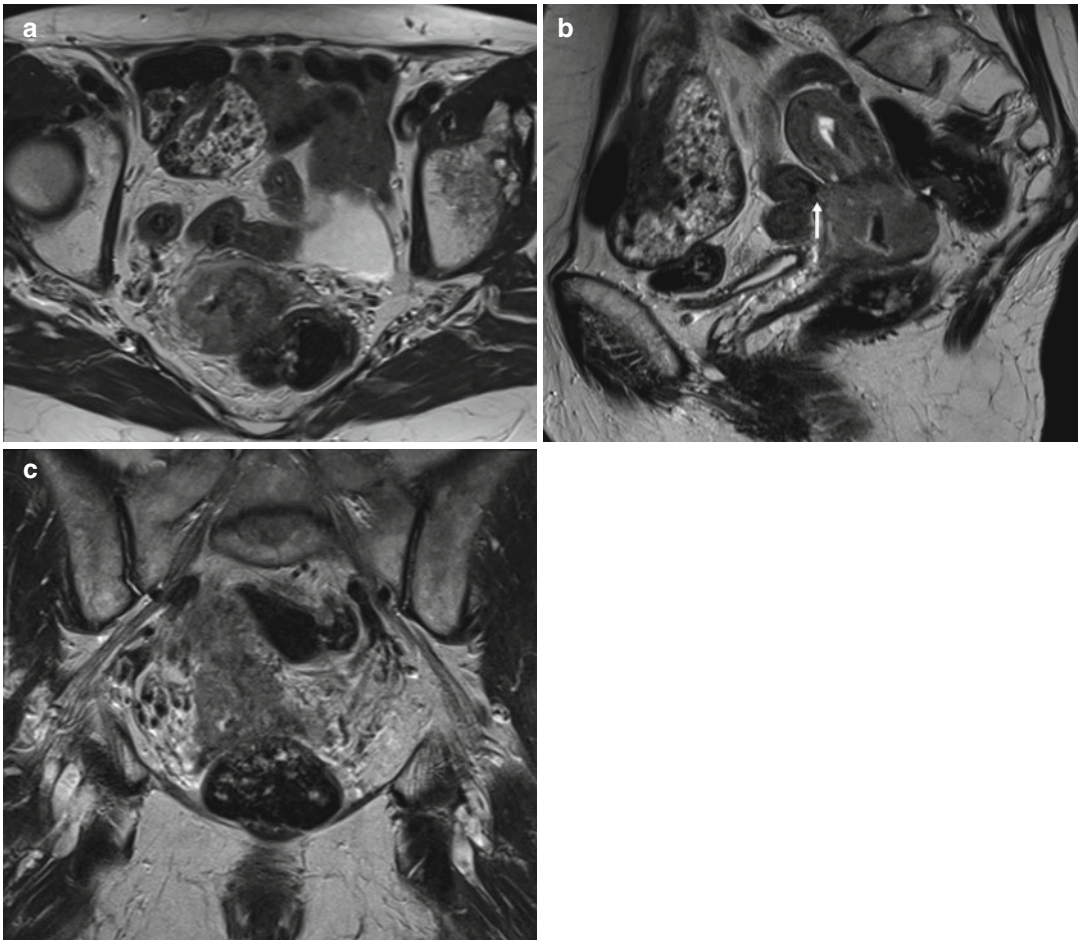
Squamous cell carcinoma of the cervix in a 79-year-old female. T2-weighted transverse (a), sagittal (b), and coronal (c) images demonstrate a large cervical mass
